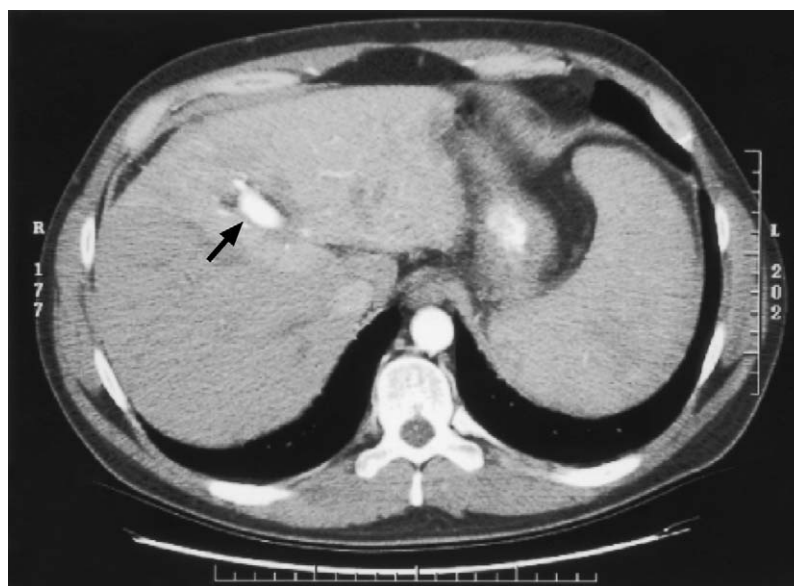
Computed tomography scan of an APF. Note the increased enhancement of the left lobe of the liver on the arterial phase. Also, there is early visualization of the portal vein (arrow).
